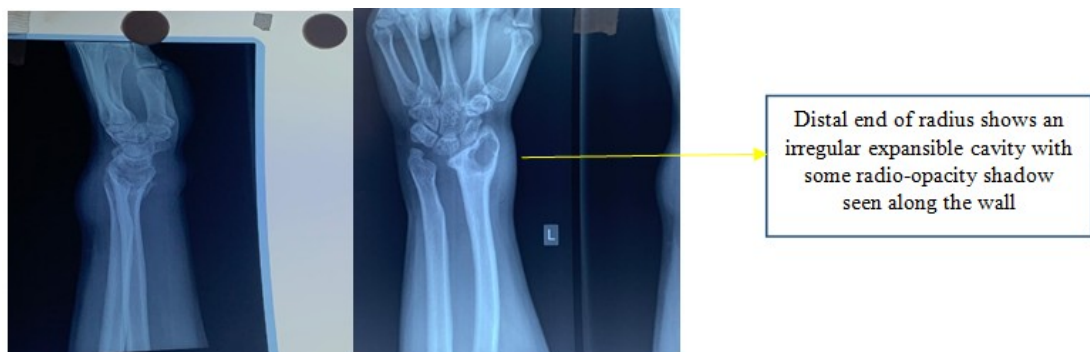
Pre-operative XRAY of left forearm showing infective site at the distal end of Radius (Lateral and AP View)
